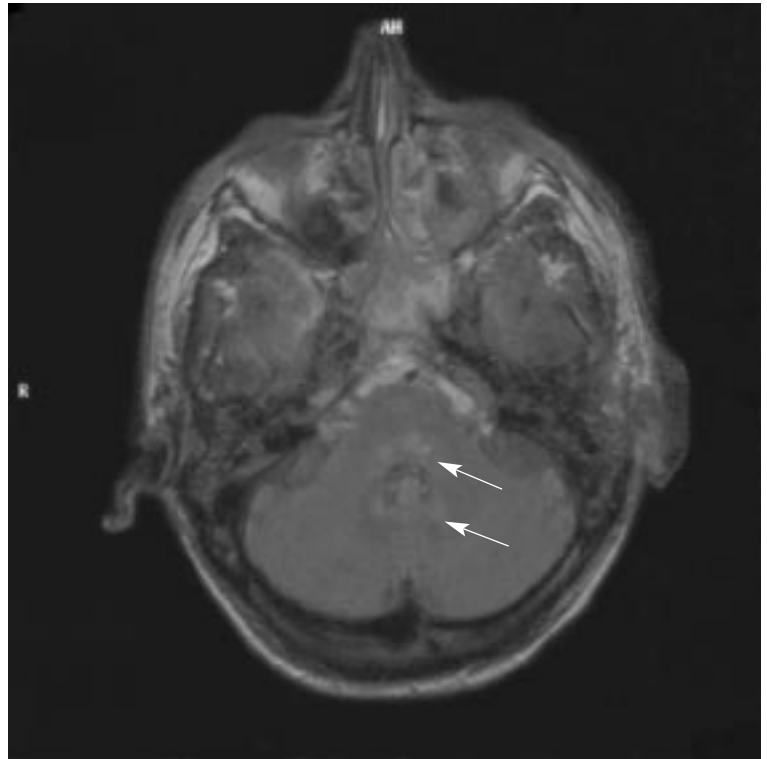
Top, MRI of the brain of a patient with West Nile fever, showing rhombencephalitis (arrows). Bottom, MRI of the spinal cord showing increased signal intensity (arrow), indicating myelitis.
